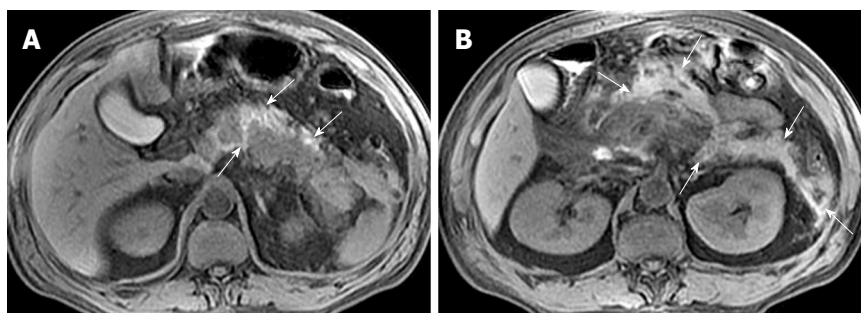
50-year-old man with acute pancreatitis. Unenhanced axial T1-weighted images with fat suppression reveal pancreatic and peripancreatic hemorrhage (arrows, A and B); Peripancreatic hemorrhage involvement include the retroperitoneal space and anterior pararenal space of the left kidney (arrows, B).
